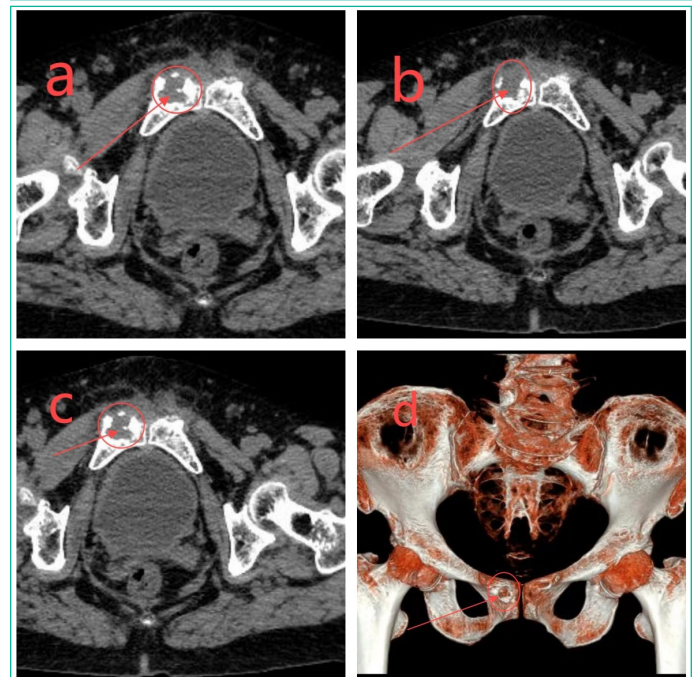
a-d) Three-dimensional reconstruction and CT scan showed: right pubic bone destruction, right pubococcygeus muscle, closed hole external muscle swelling, thin femoral muscle abscess formation.
